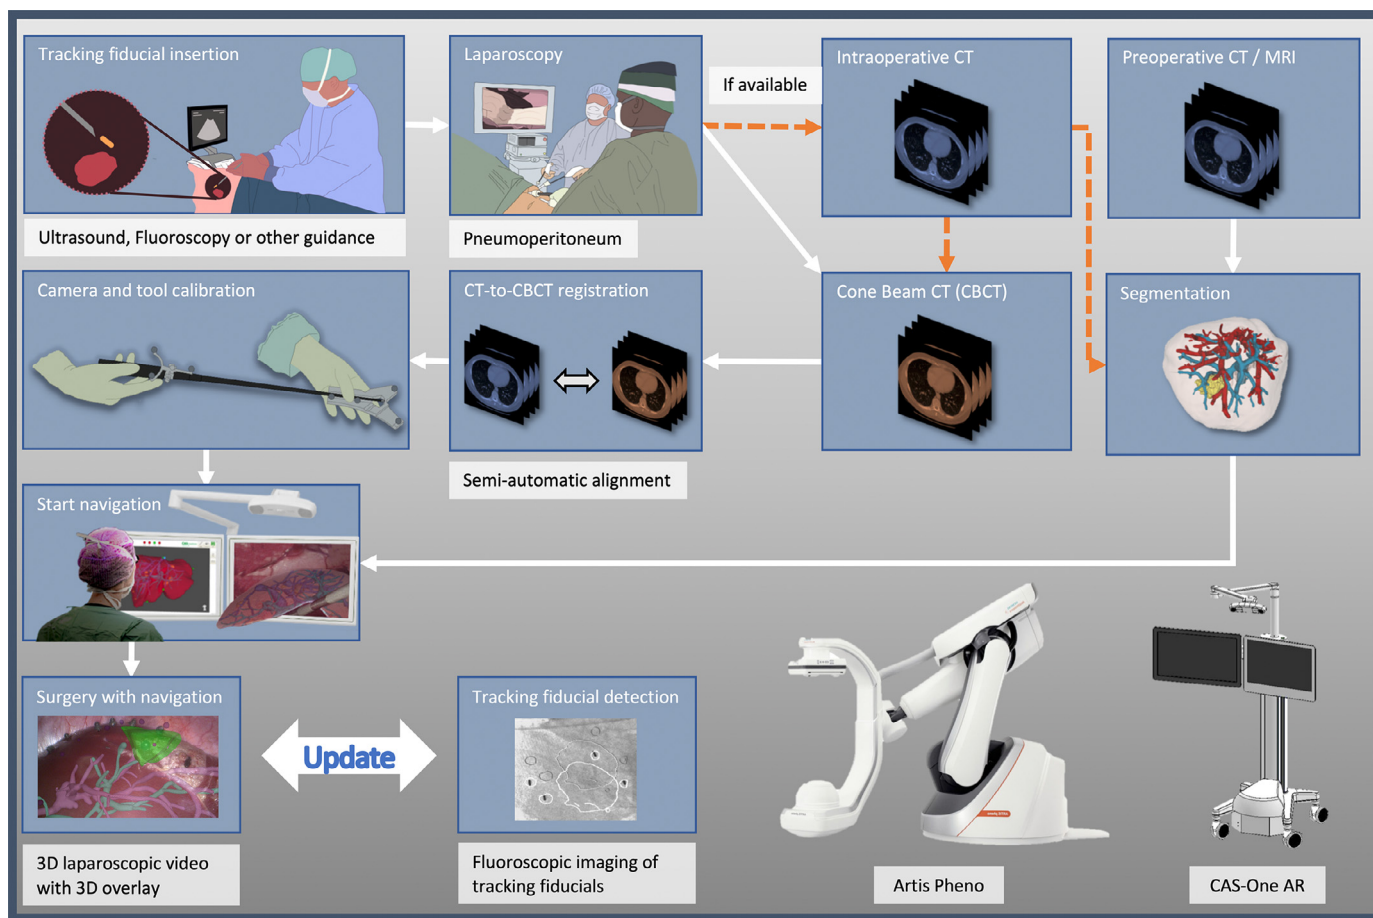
Overview of the novel navigation solution with and without intraoperative CT imaging.
